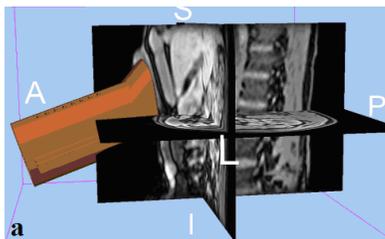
a) VIBE T1w 3D MRI images (orthogonal planes shown) and the registered US transducer's holder; b) 2nd harmonic US image of the liver; c) 2D section of the 3D MR data set along the US imaging plane; d) fused MR and color-coded edge-detection US images.
